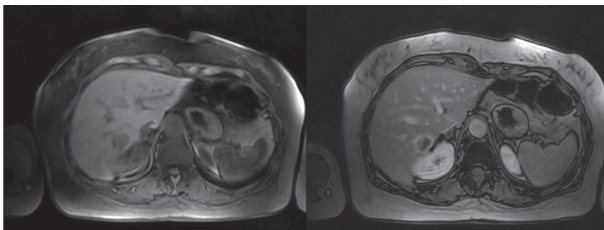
MR dynamic imaging confirms CT diagnosis of a colorectal metastase. This lesion is hypointense in T1w images before and after administration of contrast agent compared to the surrounding liver
